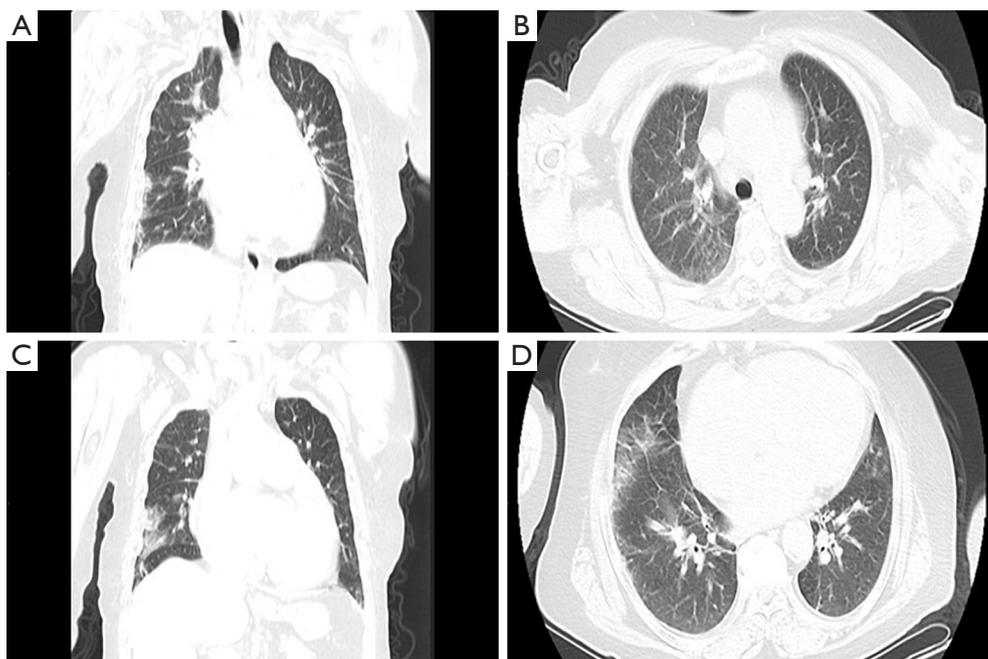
Chest imaging of the patient. Chest CT scans of the lung showed bilateral, multiple patchy, ground-glass opacities, accompanied by interlobular septal thickening. CT, computed tomography.
